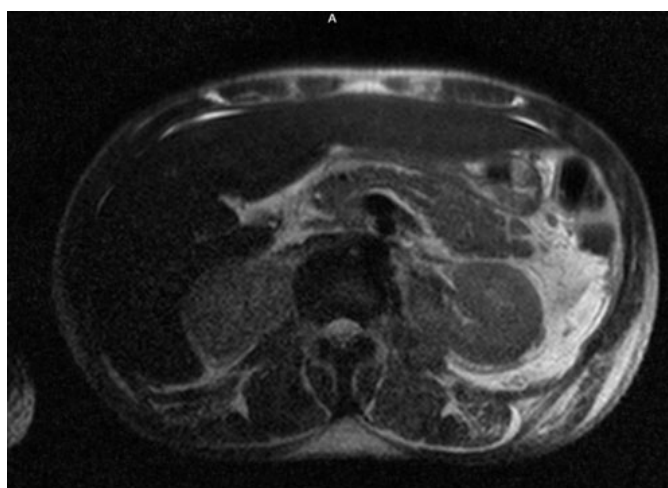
MRI abdomen without contrast—No evidence for pancreatic mass or intra-abdominal mass. Extensive peripancreatic edema as well as retroperitoneal edema extending into the pelvis bilaterally most likely related to acute pancreatitis.
